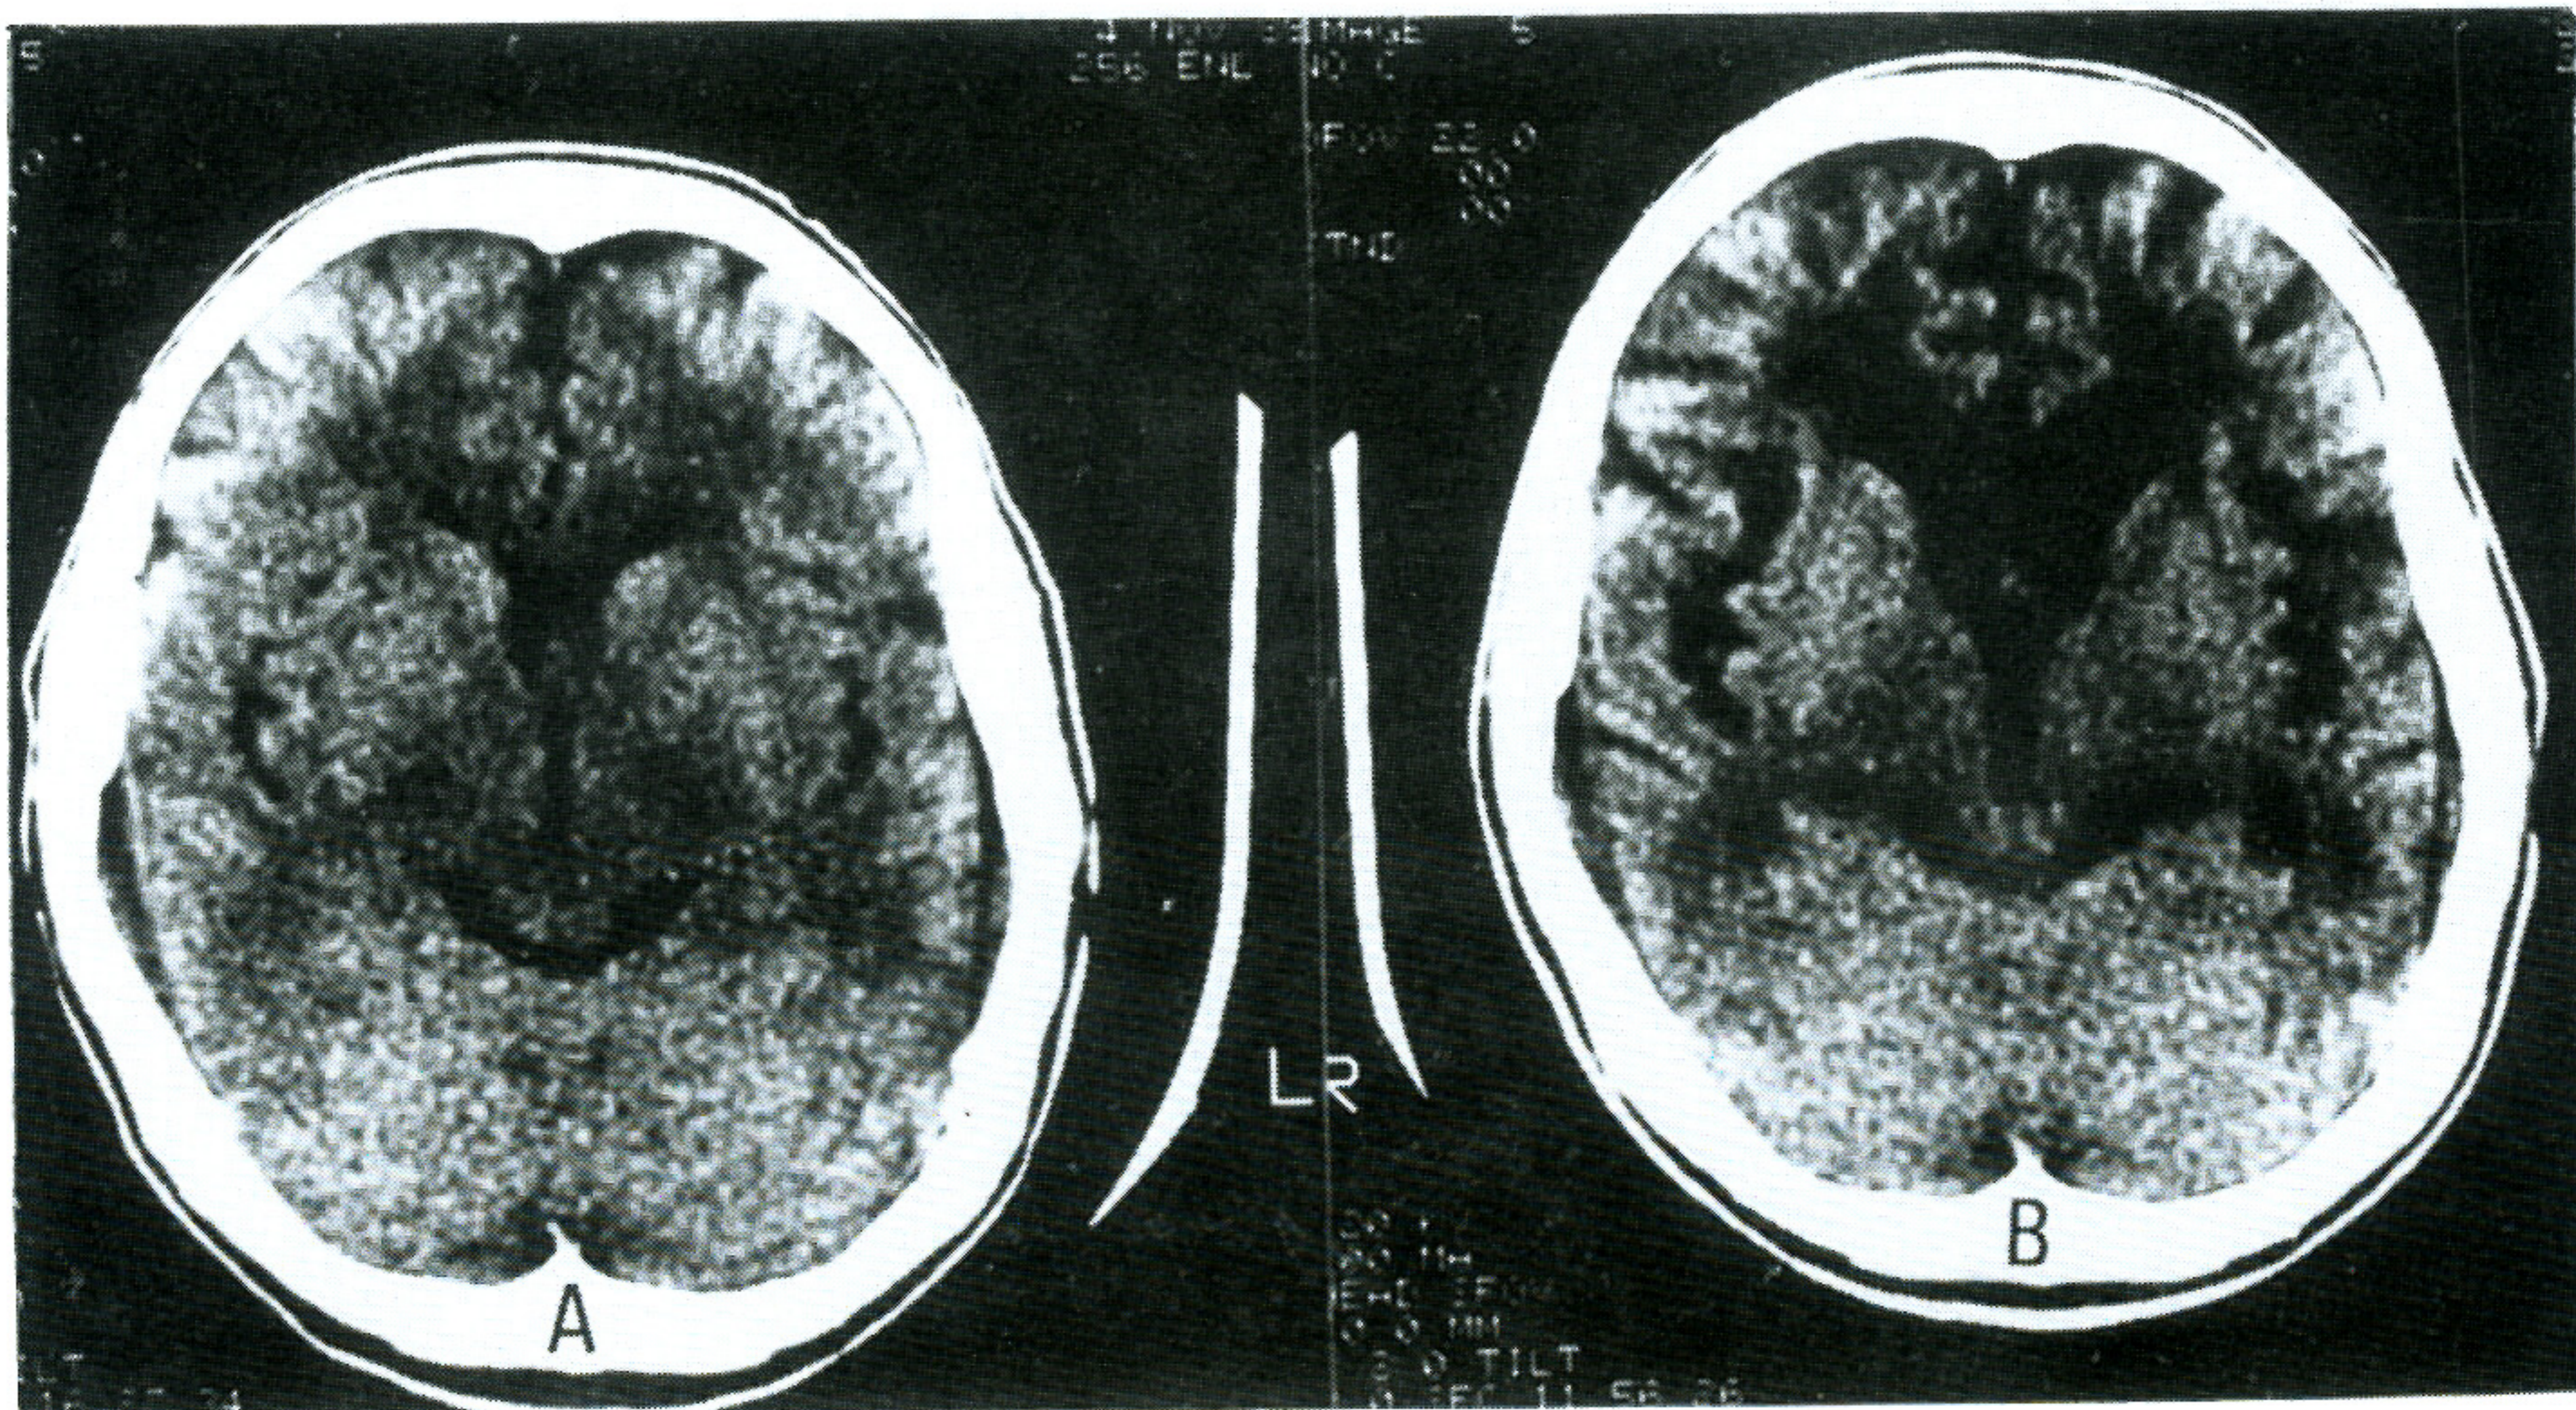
A. CT scan 4 days after acute CO poisoning showed low-density in cerebral white matter. B. CT scan 7 months after anoxia revealed a more aggravating pattern with cortical atrophy.
